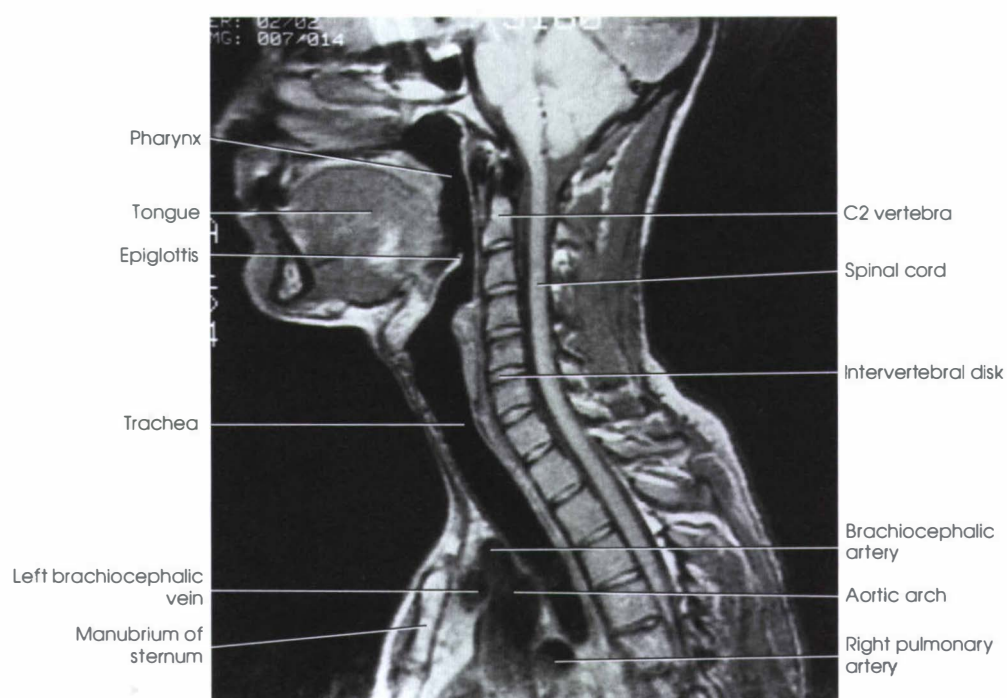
Midline sagittal MRI through neck and upper thorax.
